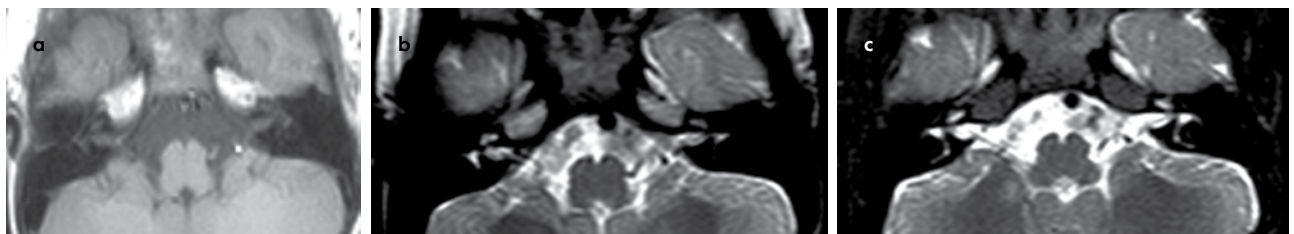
a-c. Non-pneumatized petrous apex. Bone marrow of both petrous apices reveals high T1 (a) and intermediate T2 signal (b) that significantly decreased on fat-suppressed T2-weighted image (c).
